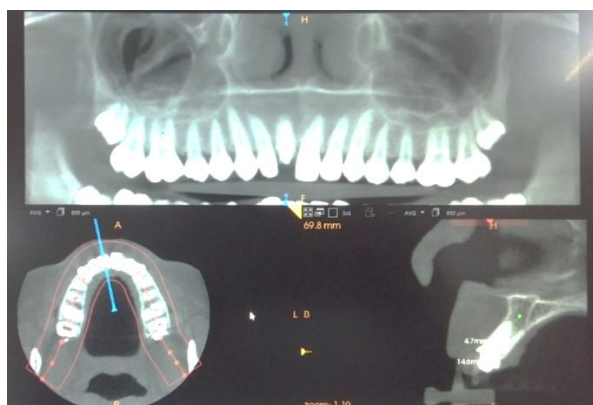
Radiograph showing the thin labial cortical plate over # 11.
